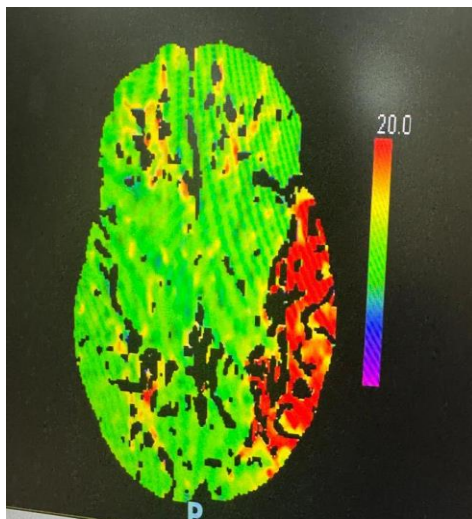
CT perfusion showing left sided infarct in MCA territory.
